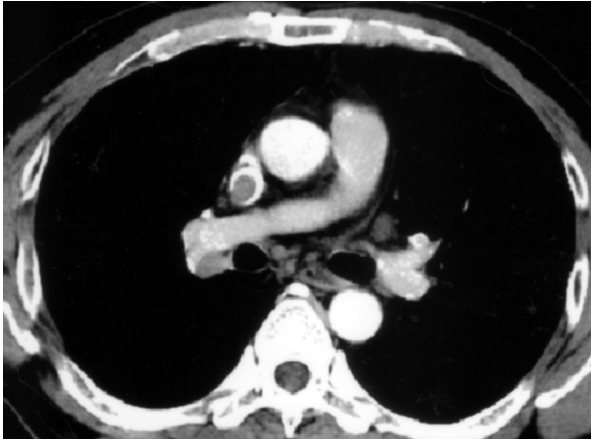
(a). Thrombus within the superior vena cava with left aortopulmonary lymphadenopathy in the chest CT.
